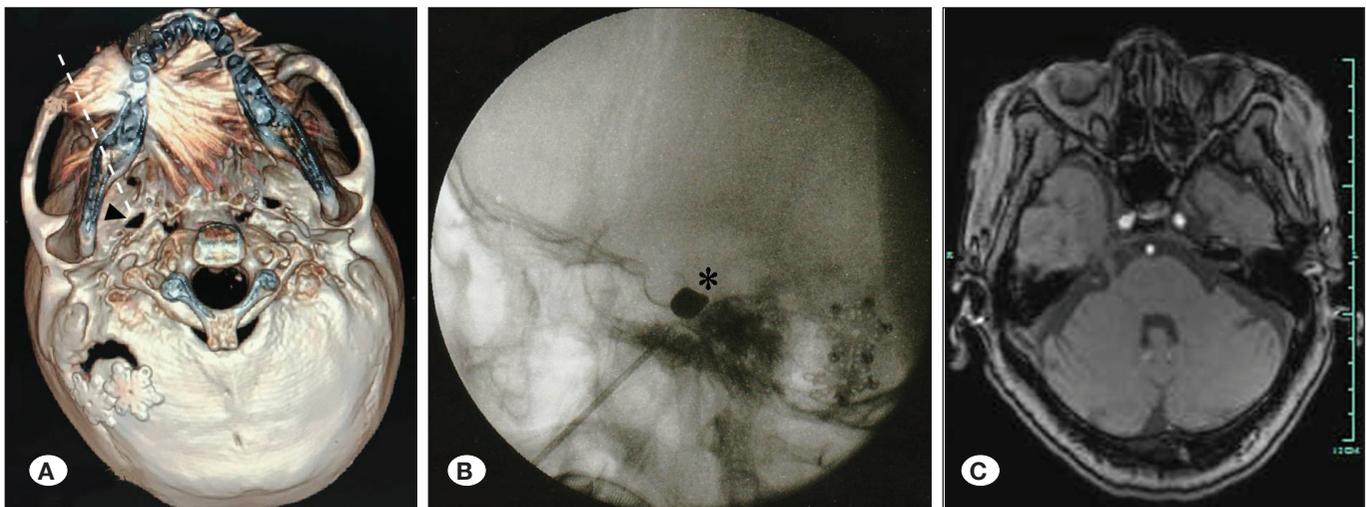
(A) 3D- computerized tomograph image of the trajectory and (B) intraoperative fluoroscopic image of PTBC, (C) MRI-TOF image to demonstrate there is no neurovascular involvement due to the procedure.
